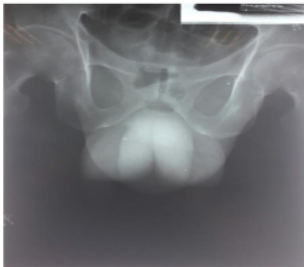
Pelvic x-ray showed gas formation in scrotal area.
